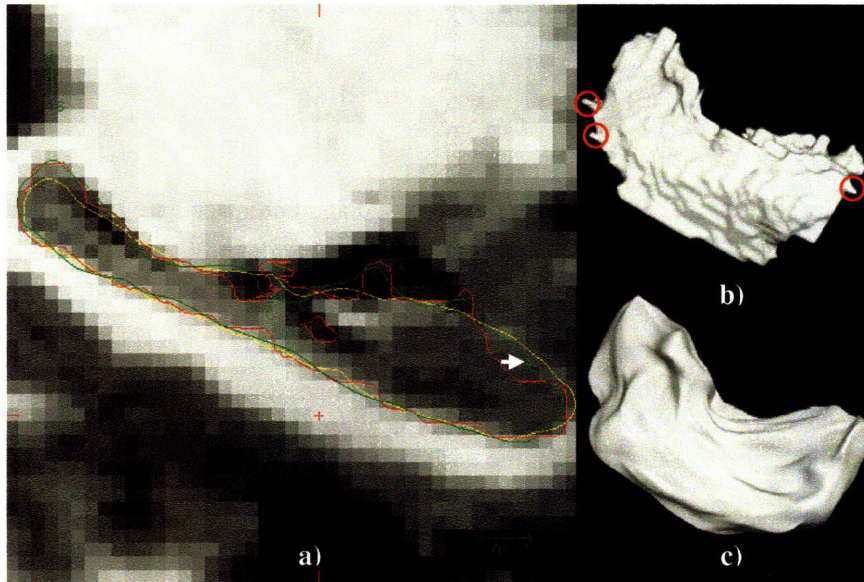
a) A sagittal slice of structure MRI image with overlaid surfaces: Manually segmented surface (yellow line), Freesurfer segmentation (red line), and new surface generated with the shape-guided segmentation method (green line). An arrow points to a region that is correctly segmented using shape-guided segmentation method. b) 3D surface rendering of the Freesurfer segmentation of the hippocampus: Red circle indicates artificial protrusion generated because of the imperfections in MR image. c) New surface generated with the shape-guided segmentation method.
